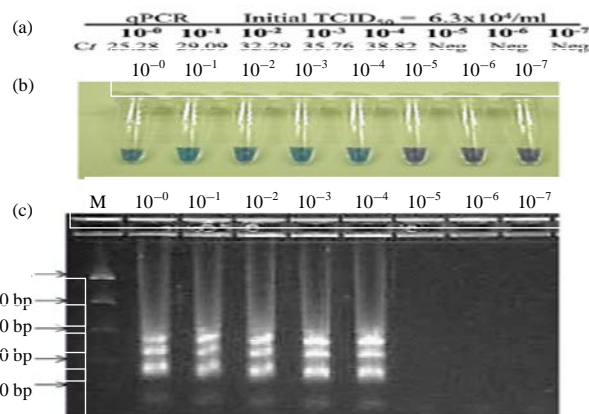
(a-c): Limit of detection (LOD) of SPV-HELD by LAMP and qPCR. SPV-HELD (TCID₅₀ = 6.3 × 10⁴ mL⁻¹) and used as the template for amplification by qPCR (a) and LAMP (b and c). Threshold cycle crossing values for qPCR are indicated (CT). LAMP was analyzed by color change using HNB (b) as well as by agarose gel electrophoresis (c)^[49]
